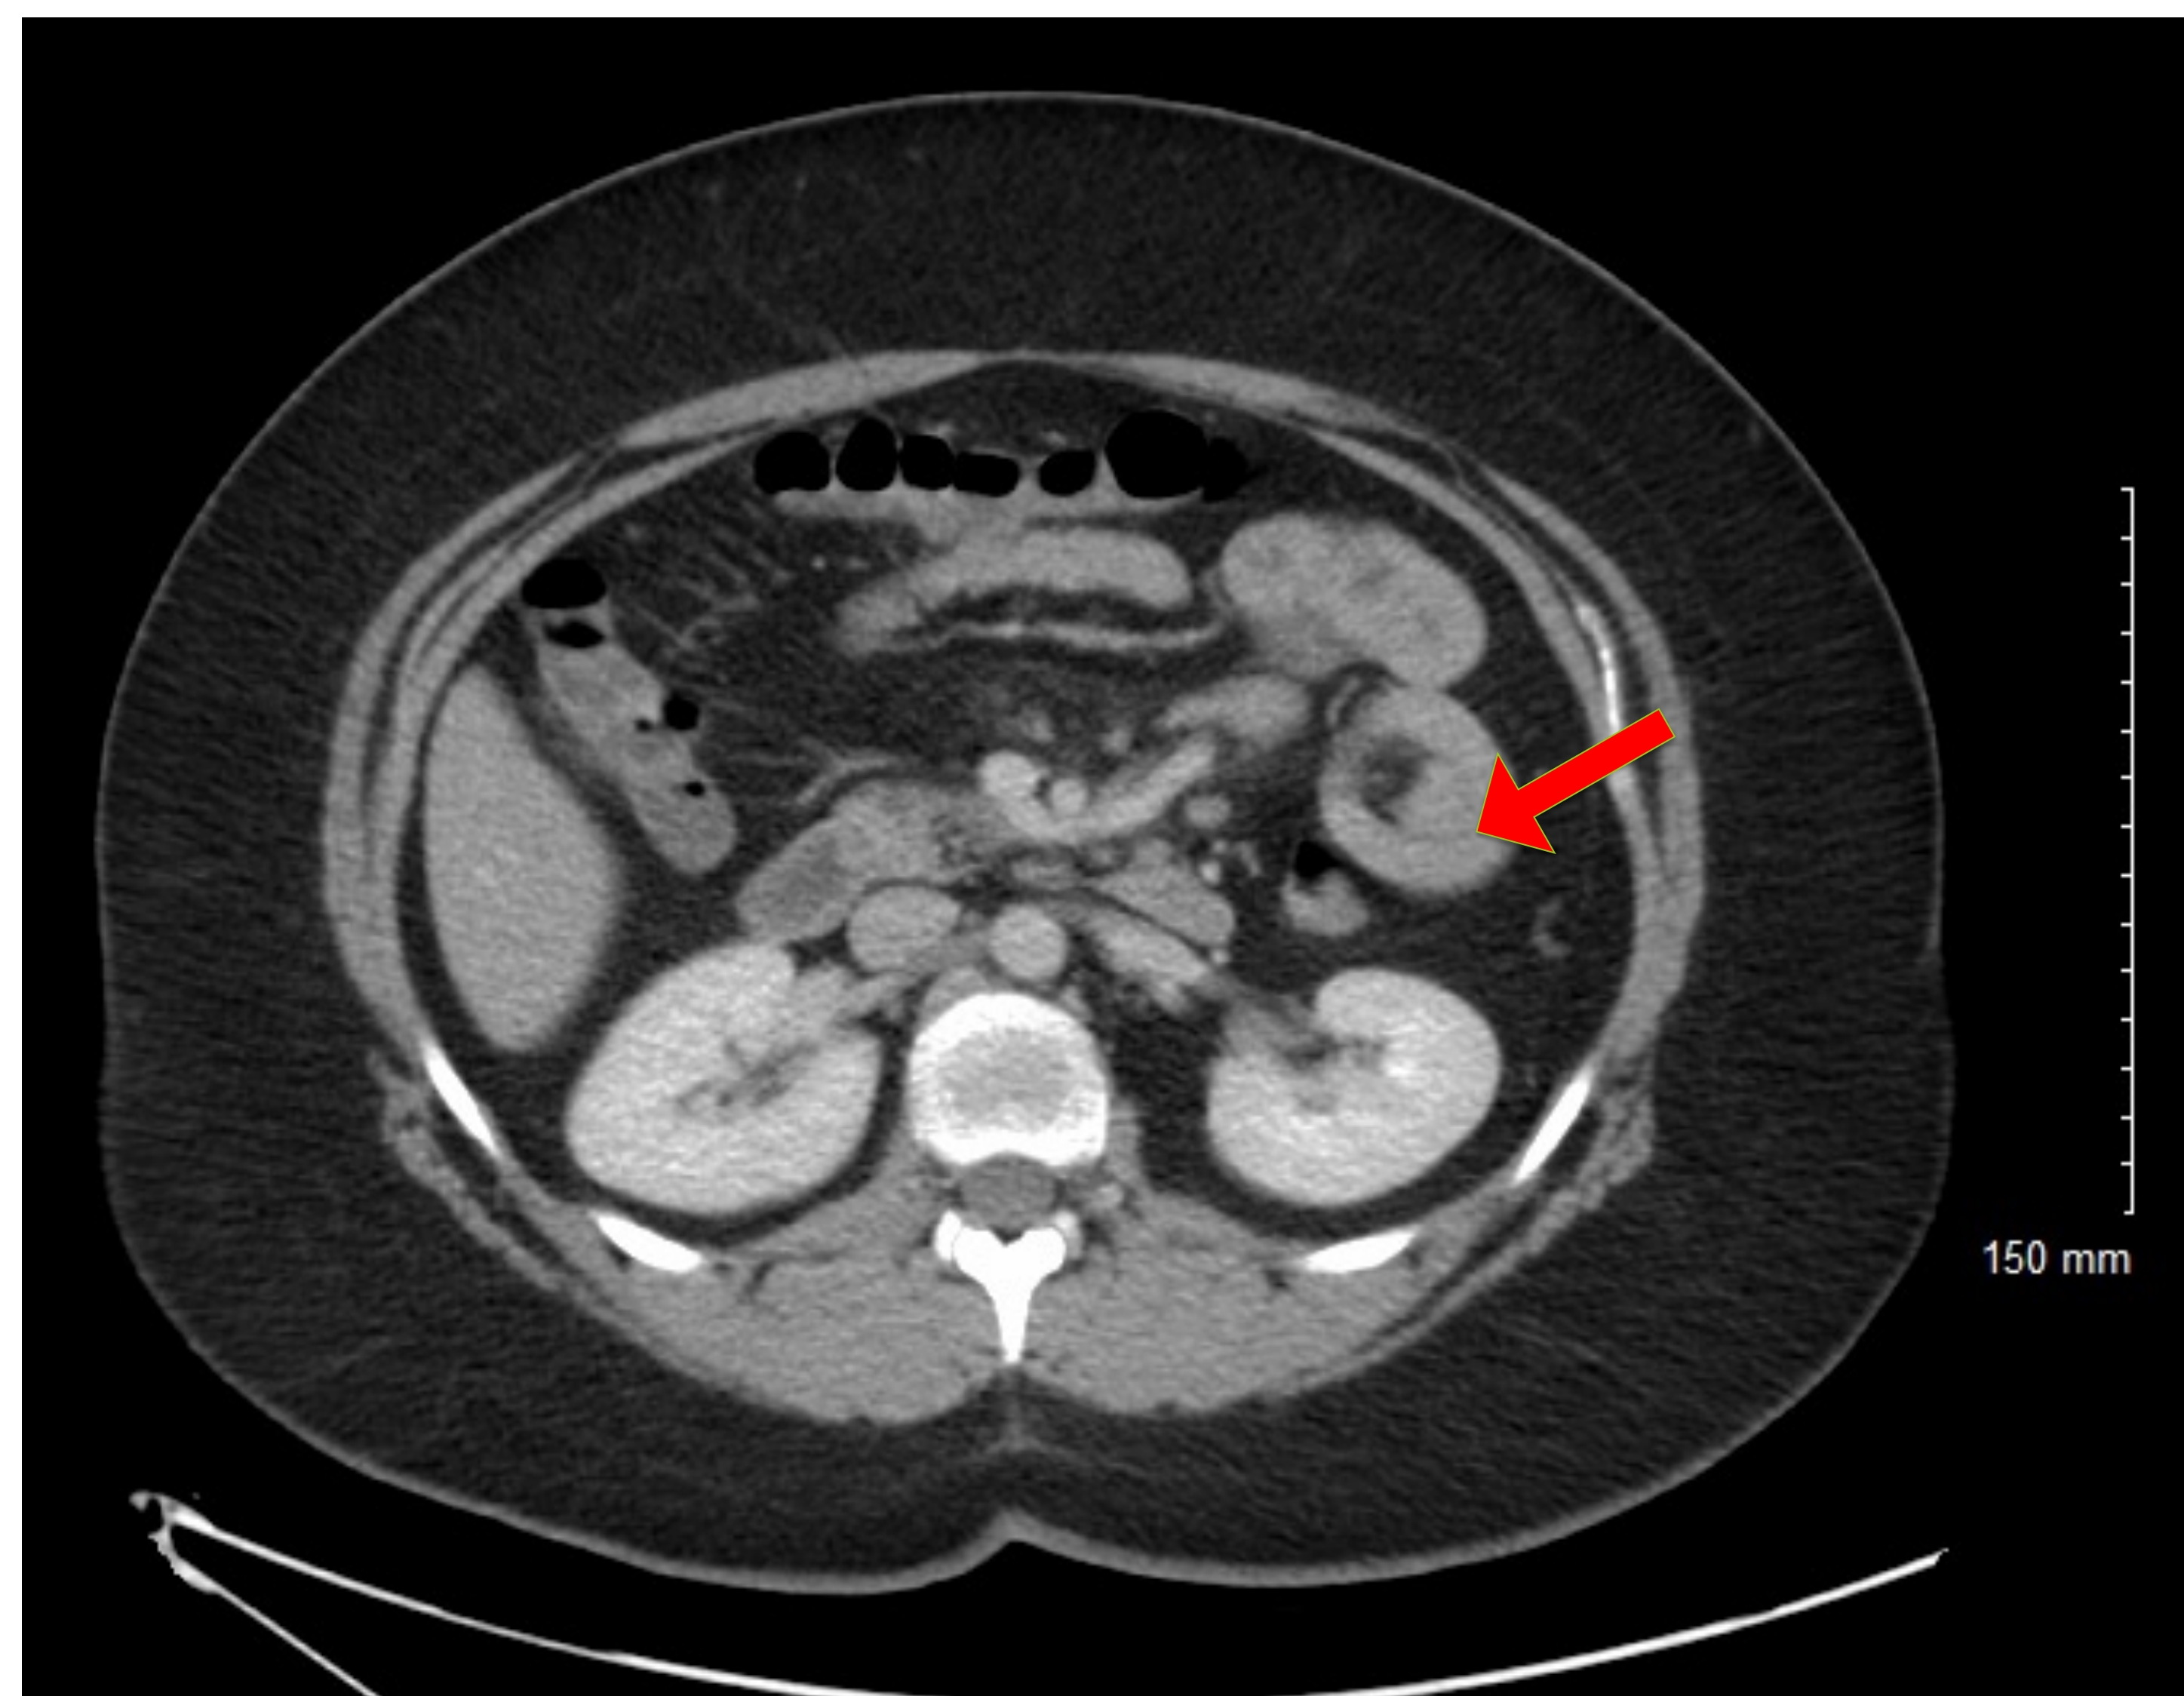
CT abdomen/pelvis demonstrating mild sclerosing mesenteritis and short segment jejuno-jejunal intussusception measuring 4.4 cm in length without evidence of inflammation, stranding or bowel obstruction.
